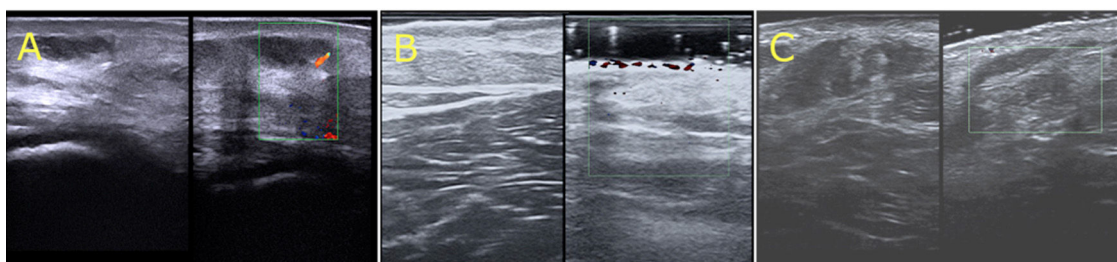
Ultrasound images of verrucous venous malformations (VVMs). A, Cutaneous ultrasound (22 MHz) of the VVM in patient 1. Thickened hyperechoic epidermis, hypoechoic dermis, hypoechoic vascular channels in the dermis and subcutaneous tissue, and absence of color Doppler signal. B, Cutaneous ultrasound (22 MHz) of VVM in patient 2. Thickened, hyperechoic epidermis with vascular channels in the superficial and deep dermis; no color Doppler signal. C, Cutaneous ultrasound (22 MHz) showing hyperechoic epidermis, decreased dermal echogenicity, and a loss of definition between the dermis and hypodermis. Note the thickened, heteroechoic subcutaneous tissue and absence of a color Doppler signal.
